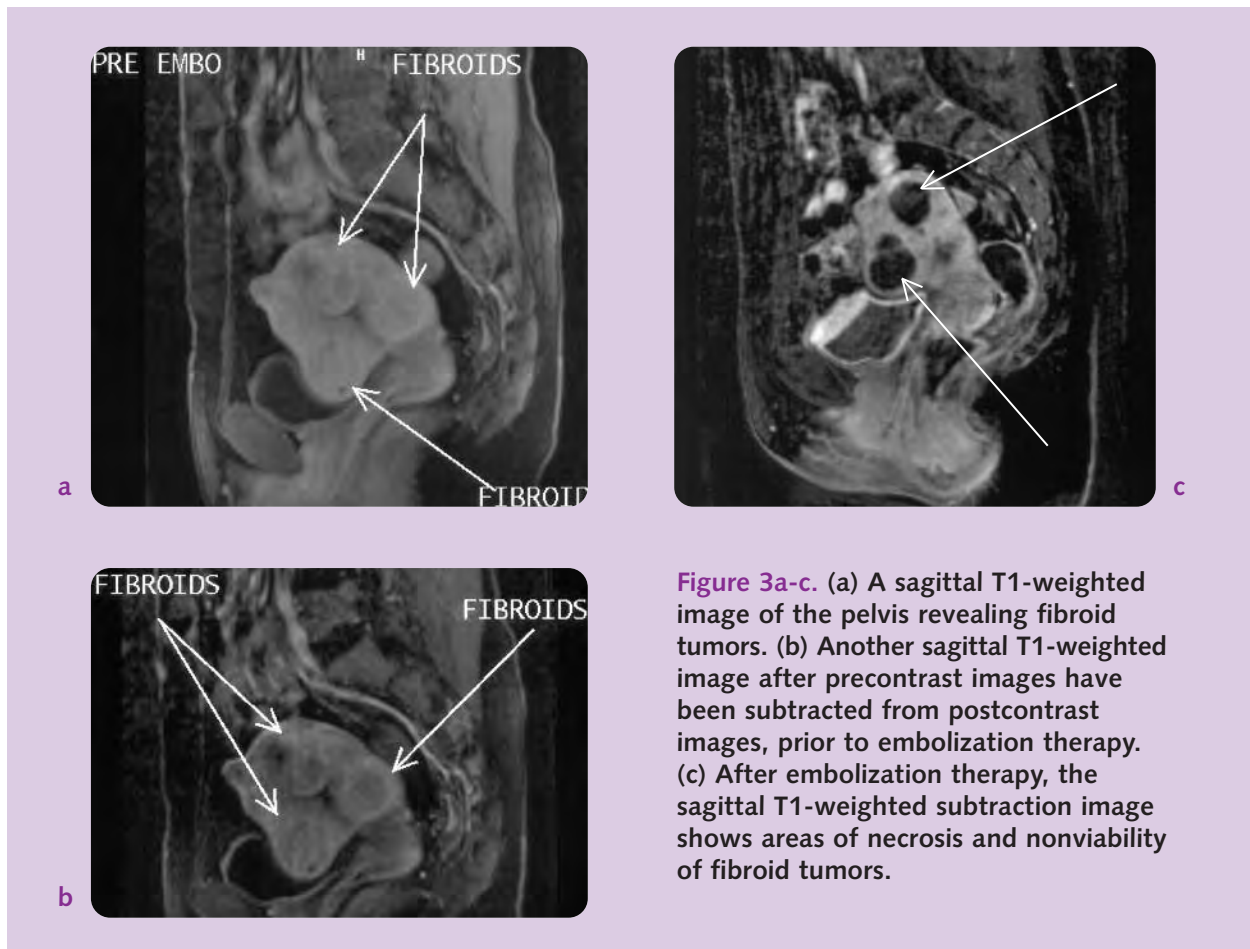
(a) A sagittal T1-weighted image of the pelvis revealing fibroid tumors. (b) Another sagittal T1-weighted image after precontrast images have been subtracted from postcontrast images, prior to embolization therapy. (c) After embolization therapy, the sagittal T1-weighted subtraction image shows areas of necrosis and nonviability of fibroid tumors.
